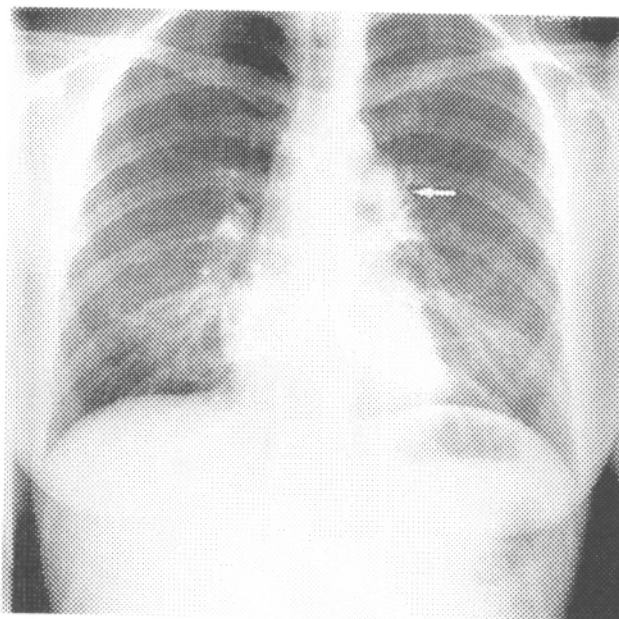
Chest radiograph of a 38-year-old female with squamous carcinoma of the thymus gland, appearing as mediastinal widening (arrow).
